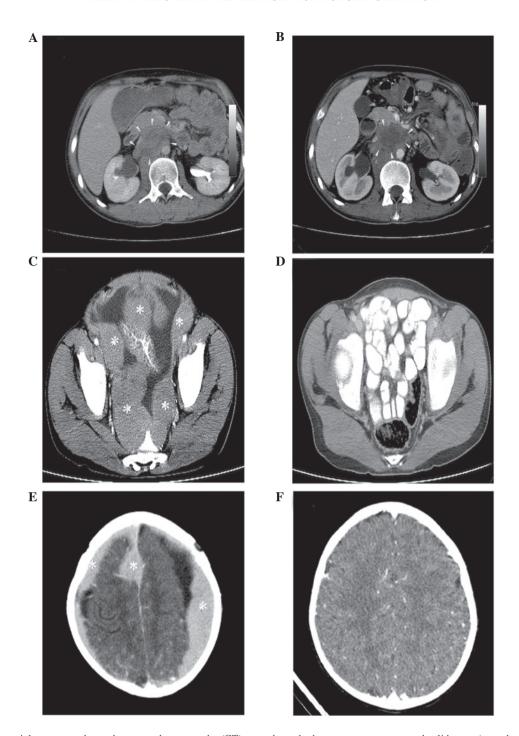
(A) The axial contrast-enhanced computed tomography (CT) scan showed a heterogeneous contrasted solid mass (arrowheads) compatible with conglomerated lymphadenopathies in the abdominal aorta-caval region. (B) Following the completion of chemotherapy, the size of the solid mass decreased and central necrosis developed (arrows). (C) The homogeneous contrast-enhancing solid masses (asterisks) compatible with conglomerated lymphadenopathies located adjacent to the iliac vessels and at the mesenteric fatty tissue were homogeneously shown by the axial contrast-enhanced CT scan. (D) The masses were not evident following treatment at the same level of the CT scan. (E) The homogeneously enhanced mass (asterisks) involving whole dura mater was evident on the axial contrast-enhanced CT scan. (F) Following treatment, no solid mass was observed at the same level of CT scan.
